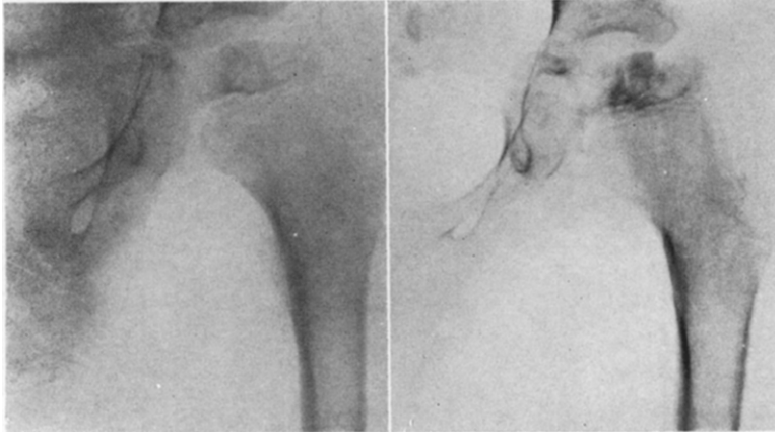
Case II. Roentgenogram April 26, 1933; irregular head with flattened contour and abnormal structure; broadened neck.
